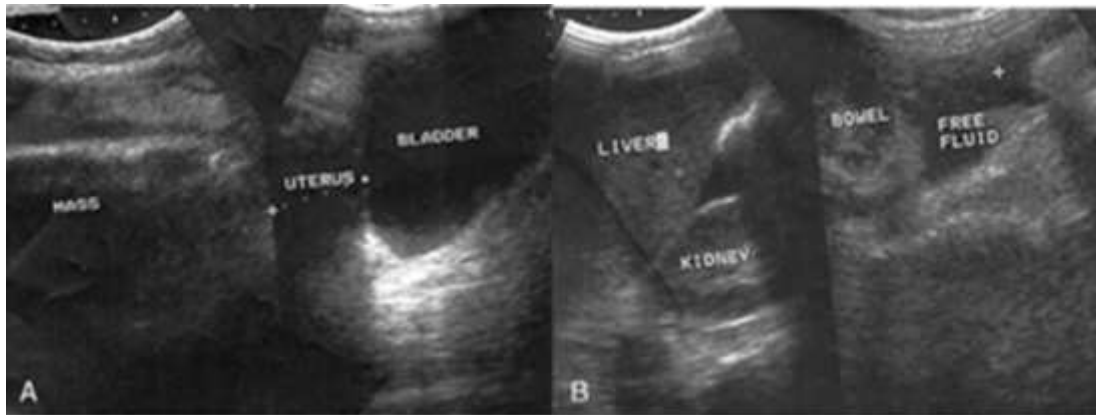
(A,B): Ultrasonographic pictures of intra-abdominal mass and viscera.
